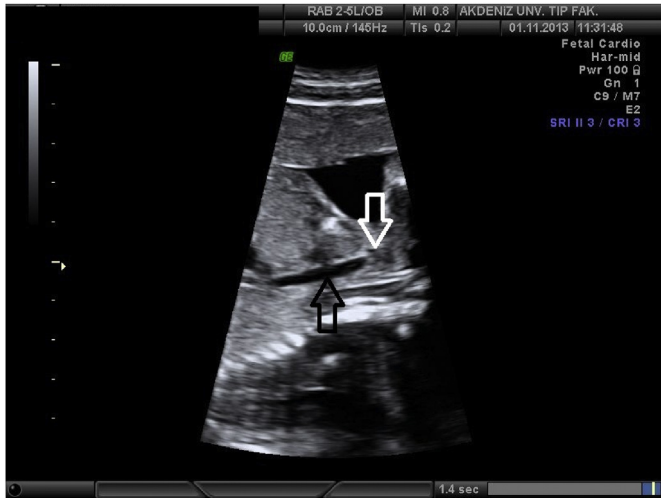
Sonographic view of dilated trachea (black arrow) and a sharp border (white arrow) between it and the occluded larynx.
